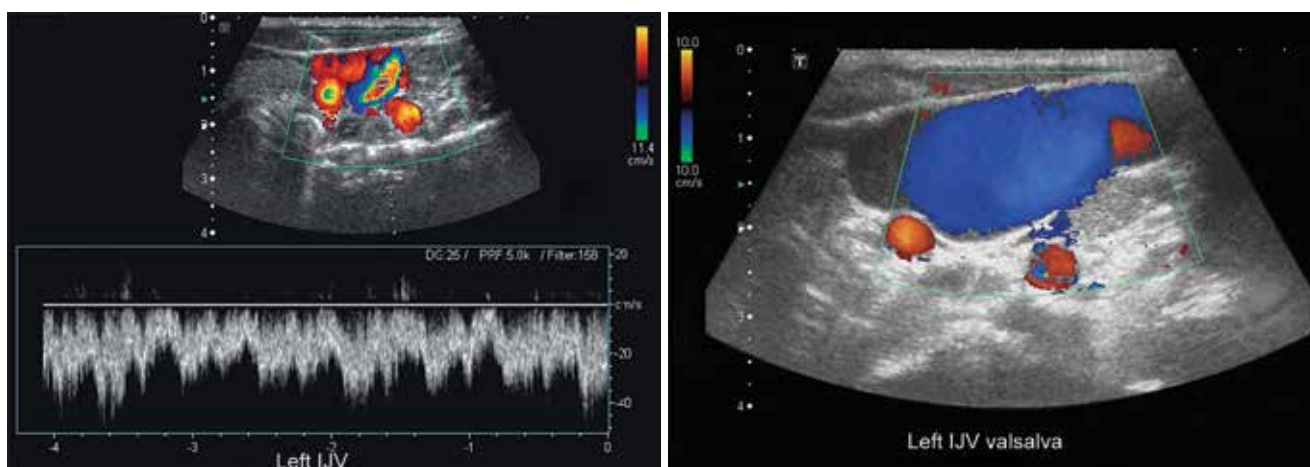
Color-flow Doppler study showing difference in blood flow in IJV at rest and with valsalva manoeuvre
